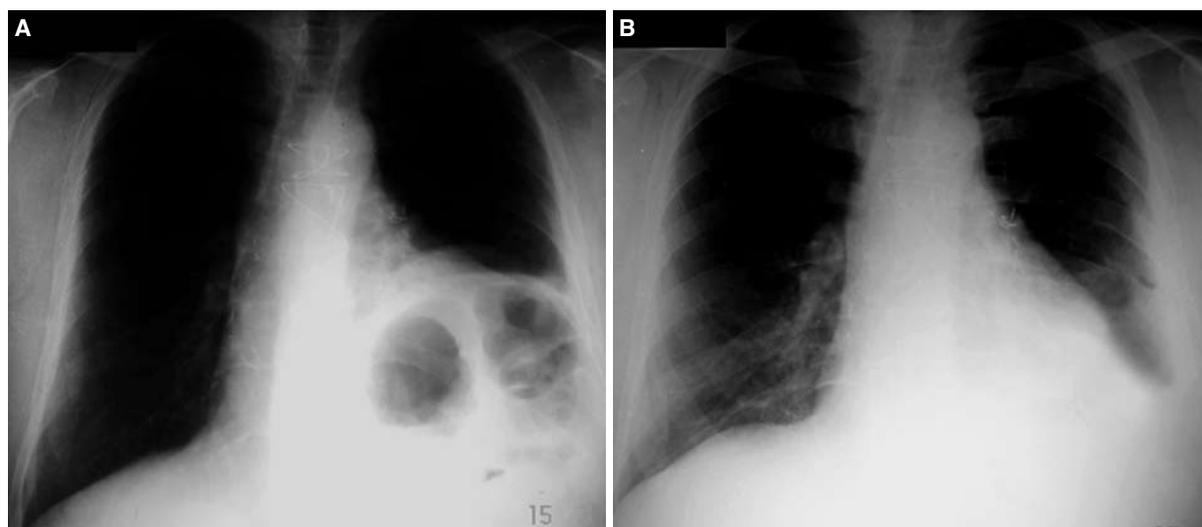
(A) Chest X-ray showing elevation of the left hemidiaphragm three days after coronary artery bypass grafting. (B) One month after plication, the diaphragm appears in its normal position.
